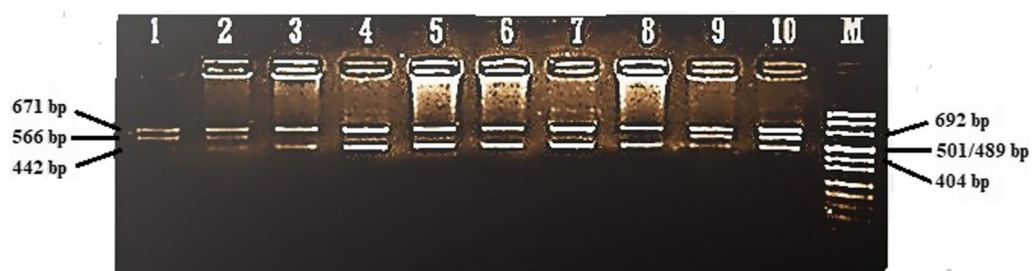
The polymorphic alleles of 3'UTR C>T polymorphism of *PHB* gene, which is defined by the *AflIII* restriction endonuclease. Lines 3, 4, 5, 6, 7 and 8: homozygous CC genotypes; lines 2, 9 and 10: heterozygous CT genotypes; line 1: homozygous TT genotype. M: pUC mix marker. The DNA marker contains the following 12 visible fragments (in base pairs): 1118, 881, 692, 501/489, 404, 331, 242, 190, 147, 111/110.
